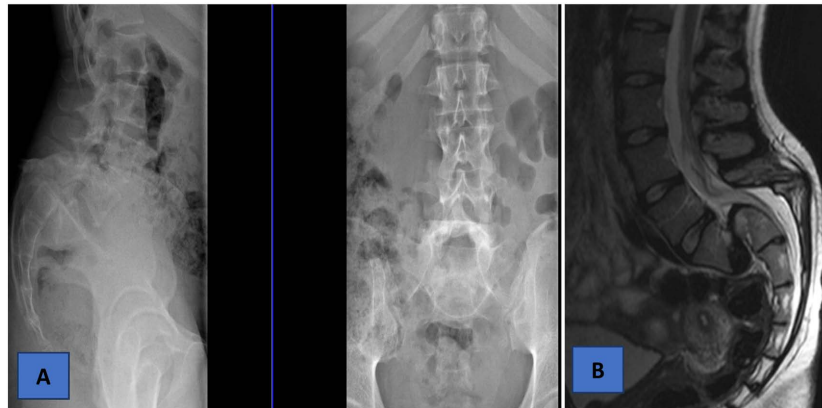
X-Ray at 9 months after surgery.
